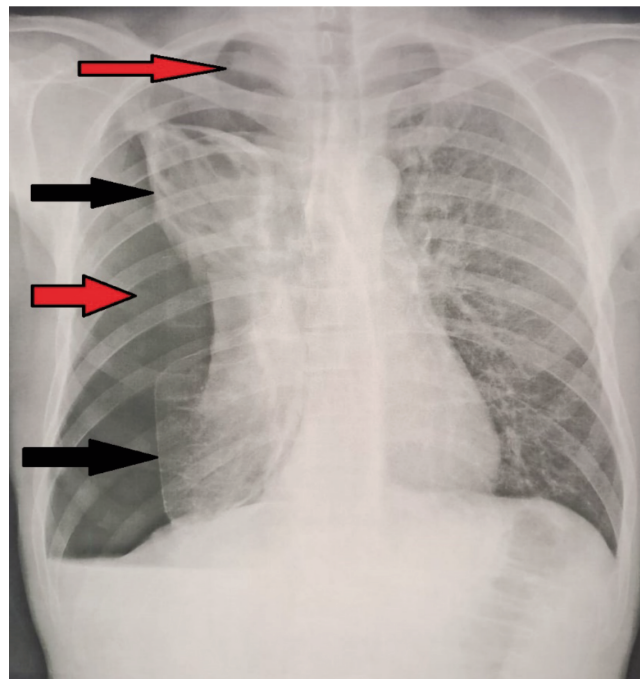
Chest X-ray showing a right-sided pneumothorax (red arrow) and the retracted pleural line (black arrow).
